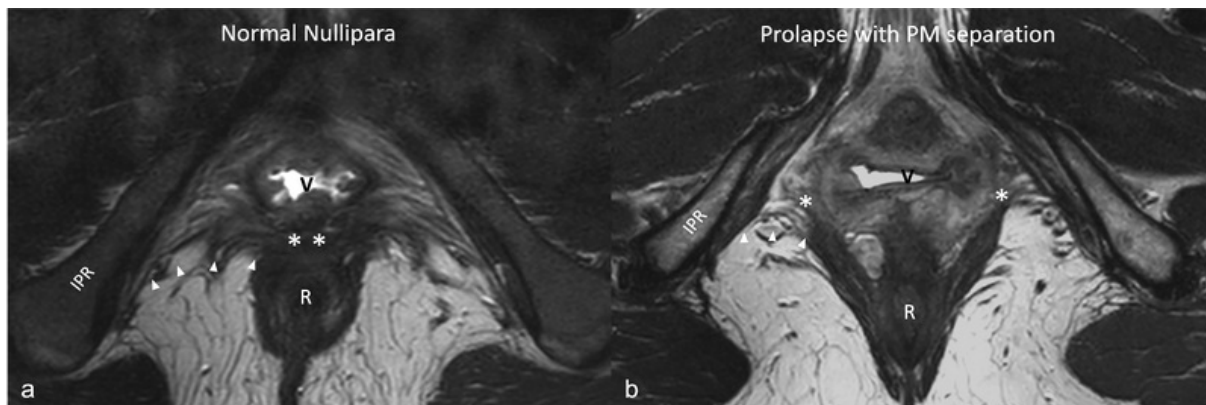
Axial MRI scans at the level of PM. Panel (a) shows a young nulliparous woman with close proximity of the two medial ends of the PM (). Panel (b) shows a woman with prolapse. Separated ends of PM are each marked (*). White arrowheads indicate the dorsal limit of PM and are placed unilaterally for comparison with other side. Abbrev.: V, vagina; R, rectum; IPR, ischiopubic ramus.
